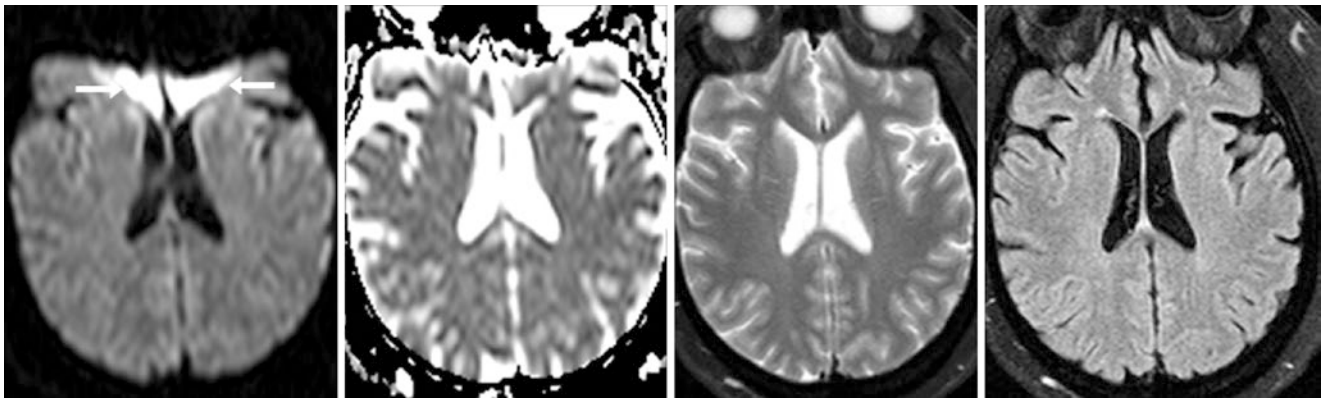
A 1.5 T MRI in a 41-year-old is affected by dental amalgam, which causes “blooming” susceptibility artifact (*arrows*) on DWI (*left*). The orbitofrontal region is obscured and does not register signal
